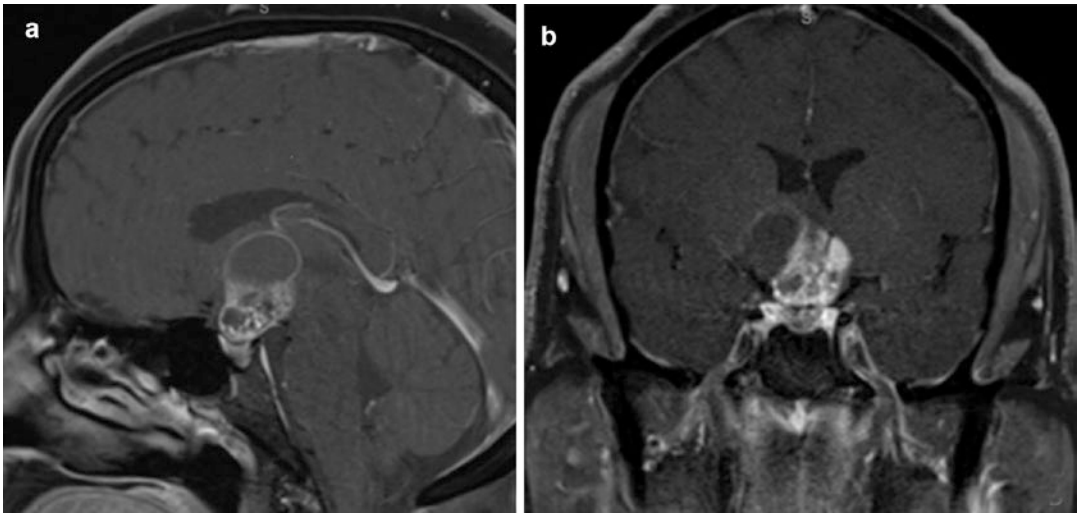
Preoperative MRI T1 with contrast sagittal (a) and coronal (b) showing the craniopharyngioma growing in the suprasellar region into the third ventricle. Note
